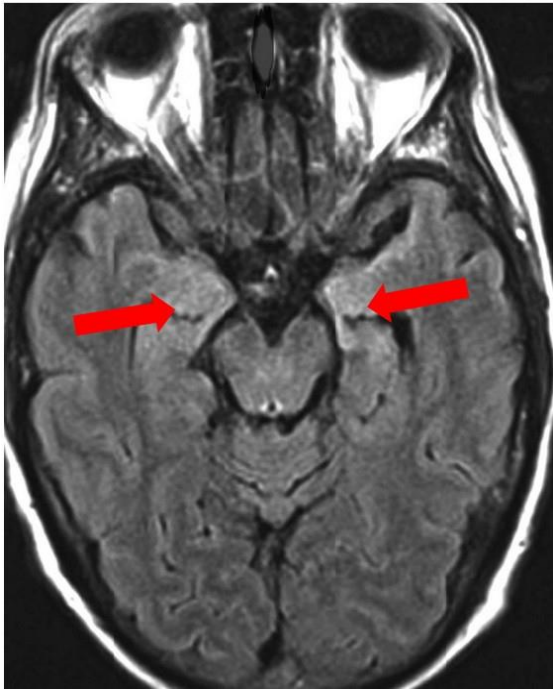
MRI of a patient with NMDAR encephalitis showing increased signal intensity bilaterally in the medial temporal lobes and hippocampi. Image taken from (Zhang et al. 2013)
